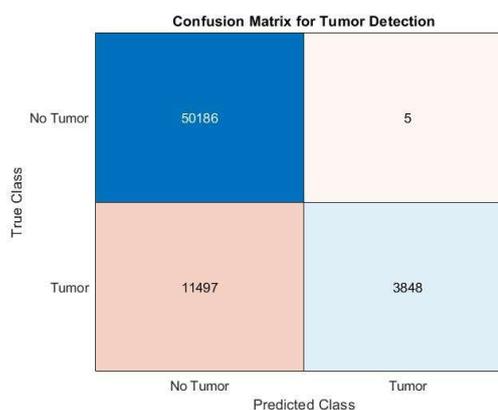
Confusion Matrix for CT Scan Image
